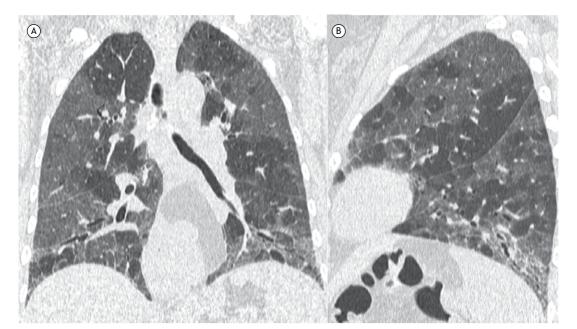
Coronal and sagittal chest CT reconstructions (A and B, respectively) showing areas of differing attenuation in the lung parenchyma. Slices obtained during expiration (not shown) revealed air trapping. Also note reticular opacities and bronchiolectasis at the lung bases.
